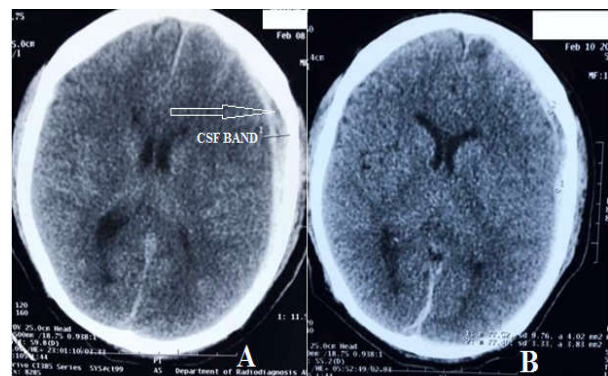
Case no. 6. (A) Initial CT head showing left side acute SDH and CSF band (arrow), (B) Repeat CT head of same patient having rapid spontaneous resolution of SDH
